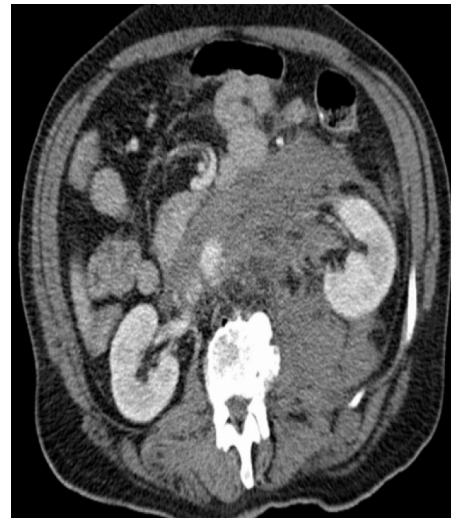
An axial CT scan view
